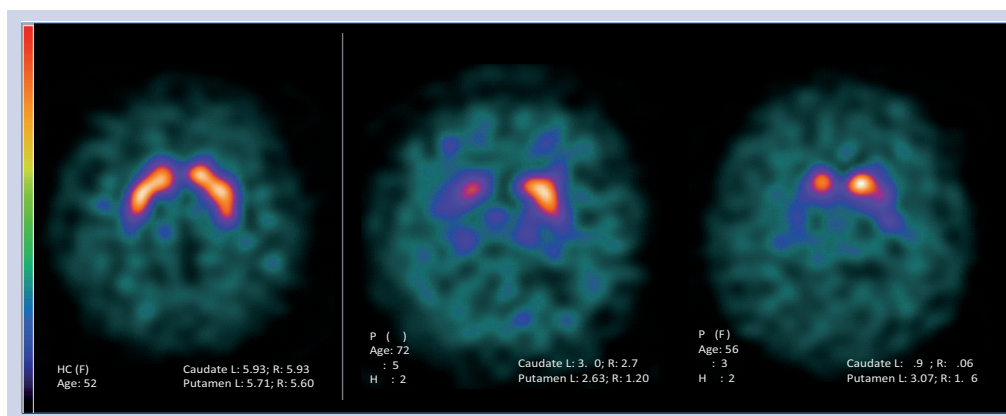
$[^{123}\text{I}]\text{FP-CIT}$ of healthy controls and Parkinson's disease subjects. $[^{123}\text{I}]\text{FP-CIT}$ SPECT images and binding values of healthy subjects and patients with Parkinson's disease or atypical degenerative parkinsonism.
